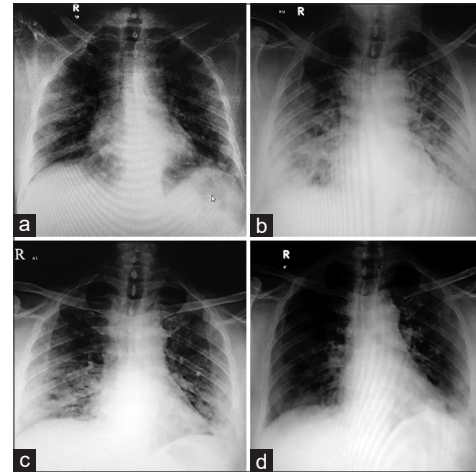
(a) Chest X-ray of Covid-19 patient - day 1. (b) Chest X-ray of Covid-19 patient - day 2. (c) Chest X-ray of Covid-19 patient - day 6. (d) Chest X-ray of Covid-19 patient - day 10
